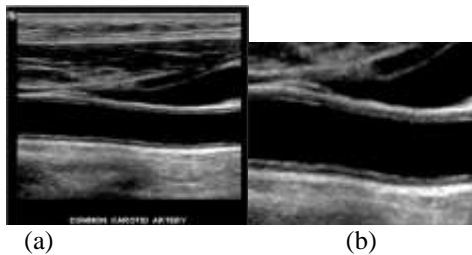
(a) Input ultrasound image. (b) Cropped image.
